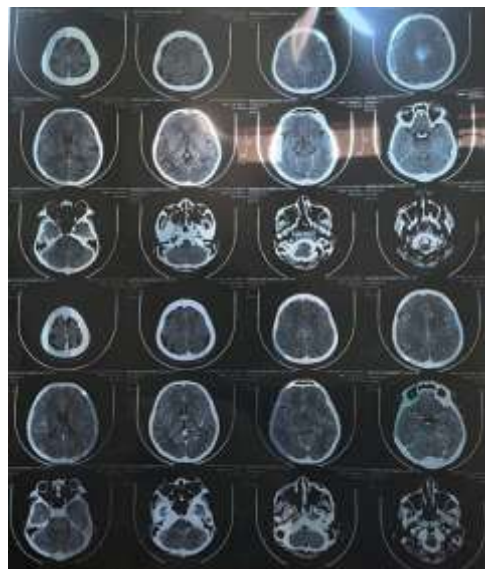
Head CT Scan Without Contrast
